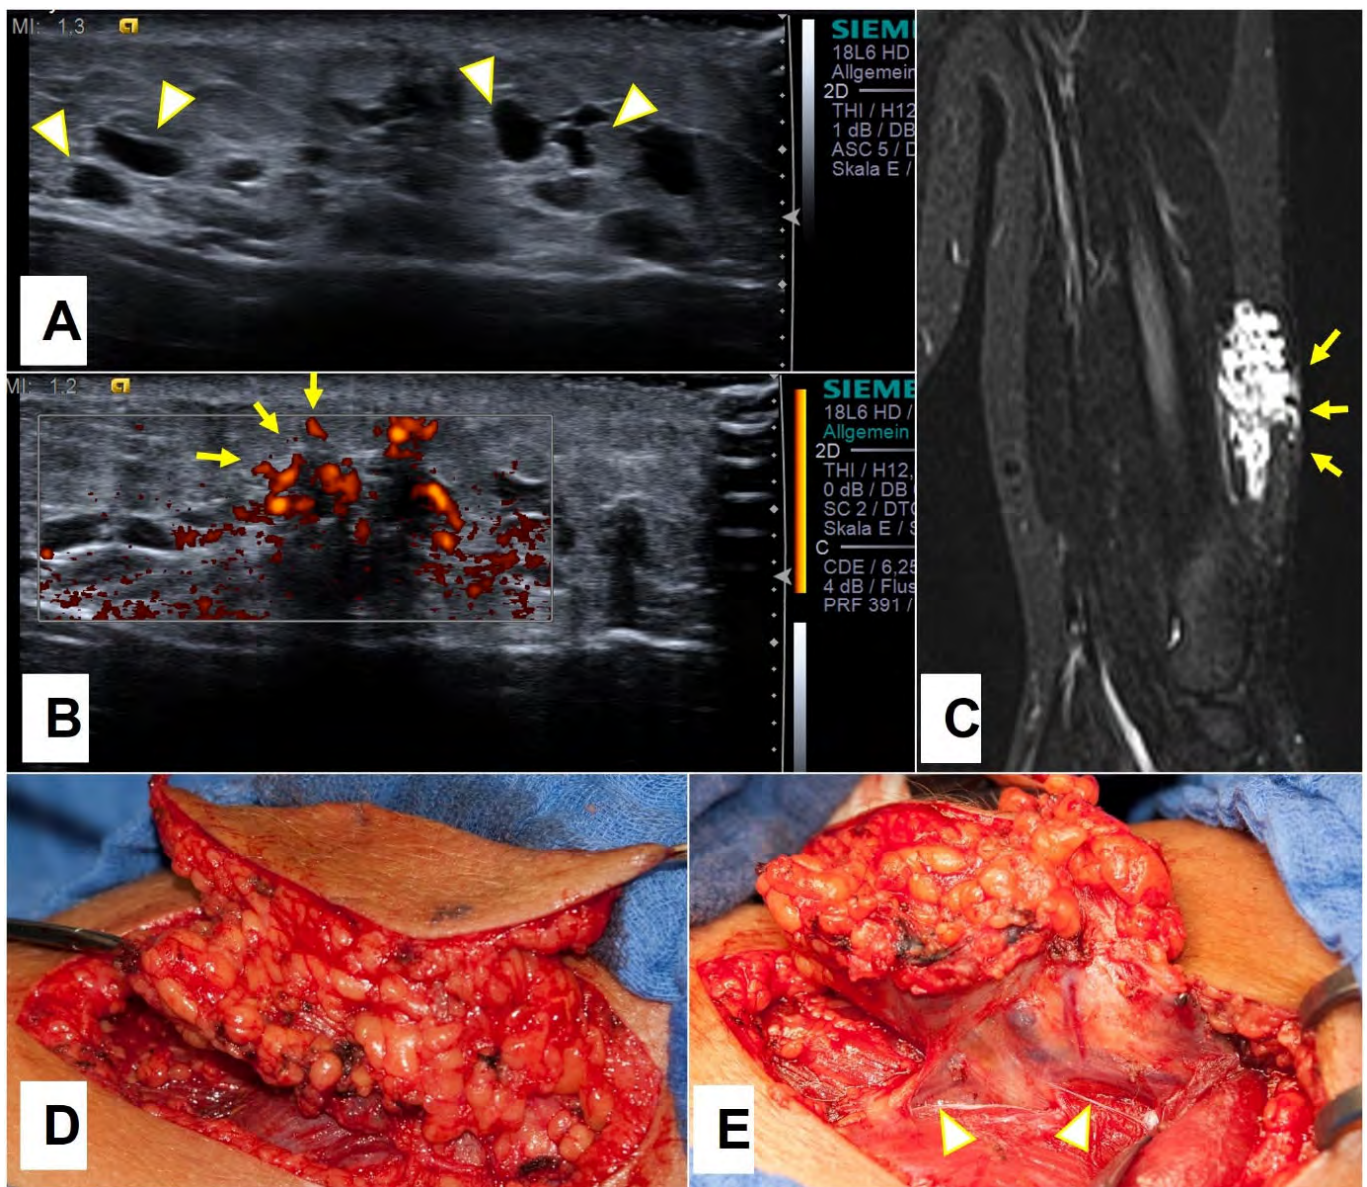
A 14.5-year-old boy was presented because of the minor swelling on his left upper arm, which appeared after he started to go to the gym. Ultrasound imaging showed a tubulo-cystic lesion (arrowheads) on the lateral aspect of his upper arm (A) which showed perfusion (arrows) in a power Doppler mode with venous flow characteristics (B). MRI depicted a venous malformation (arrows) of the localized extension located in the subcutaneous area (C). Complete excision of the VM was performed (D). Draining veins are depicted with arrowheads (E).
